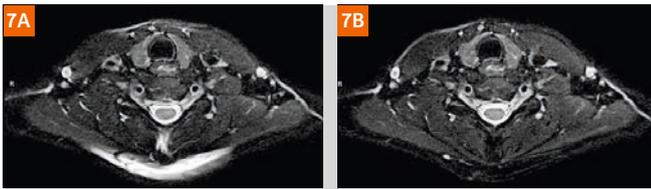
T2-weighted BLADE images with SPAIR fat saturation. The same imaging protocol was used with (7A) and without (7B) CoilShim. The fat saturation is more homogeneous when CoilShim is active.
